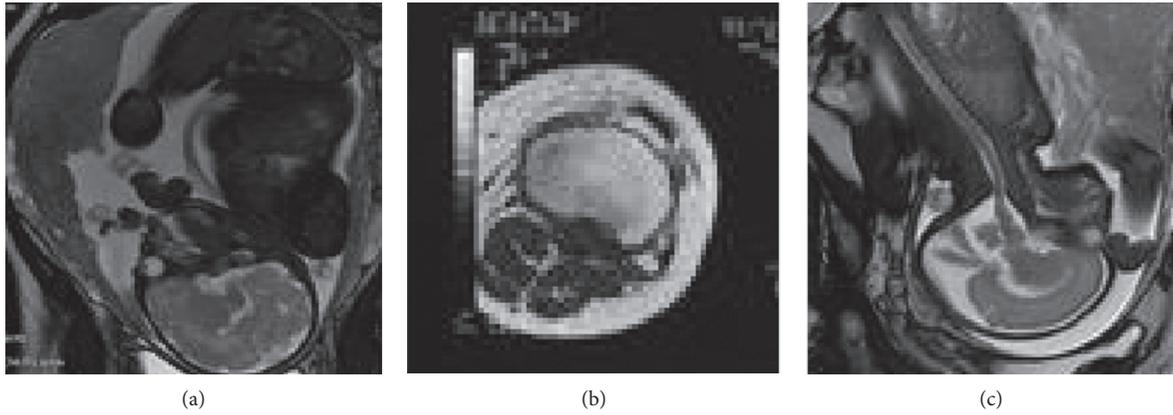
MRI images of patients with EC: (a) the image after DWI examination; (b) the image after T2WI examination; and (c) the image after T1WI+C examination.
